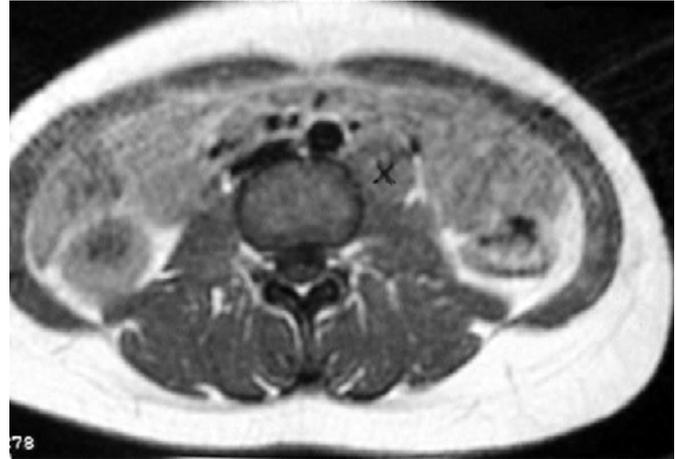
T₁-weighted abdominal MR image in patient 2 revealing para-aortic lymphadenopathy (crossed lines).
